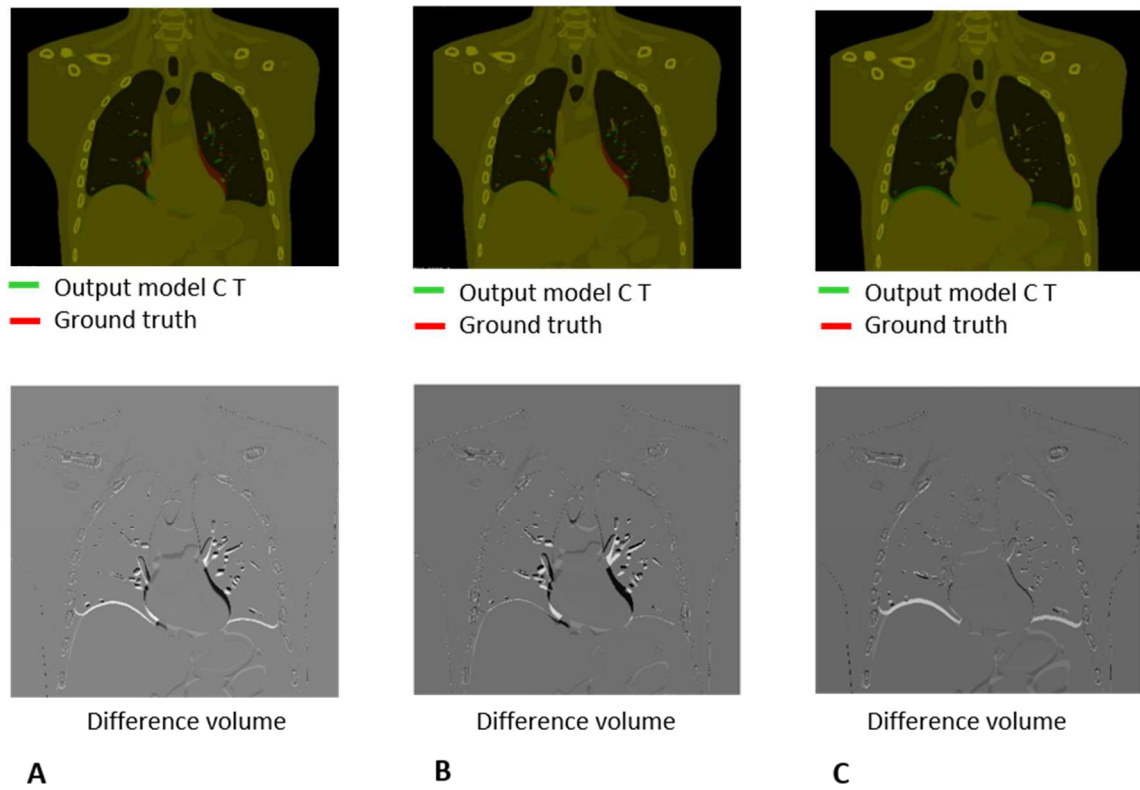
MidP as reference-Fayad's model: model output CT of Fayad's model when the MidP volume is used as reference.
